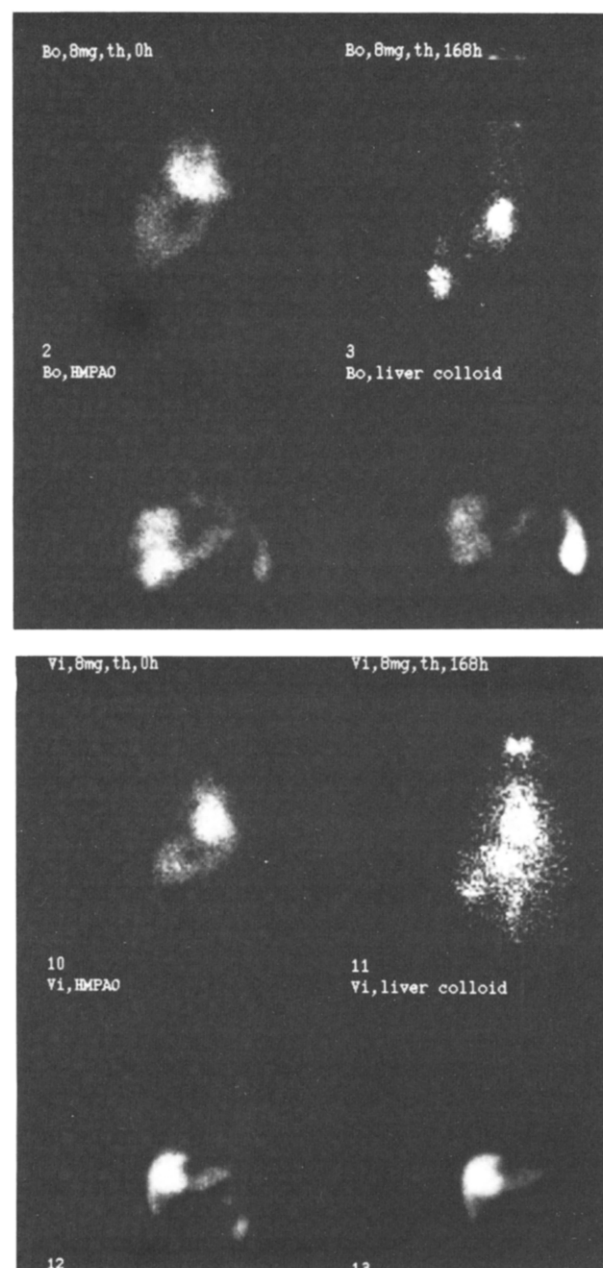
Patients I-3 (upper) and I-5 (lower) were known with various liver metastases. Initially at day 0, in both patients immunoscintigraphy showed "cold" lesions after ¹³¹I-16.88 infusion which filled up with radioactivity to "hot" areas (shown at day 7). Apart from the metastases in patient I-5 uptake is still visible in the heart region at day 7. Liver images obtained with ^{99m}Tc-HMPAO and ^{99m}Tc-colloid confirmed metastatic sites with poor blood supply.
